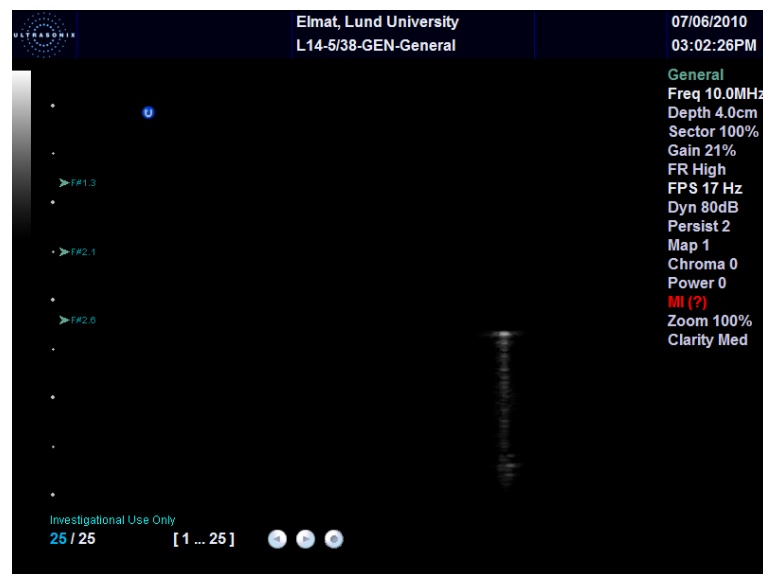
Ultrasound images of the blood-filled capillary in intralipid. Note the presence of artifacts under the capillary.
